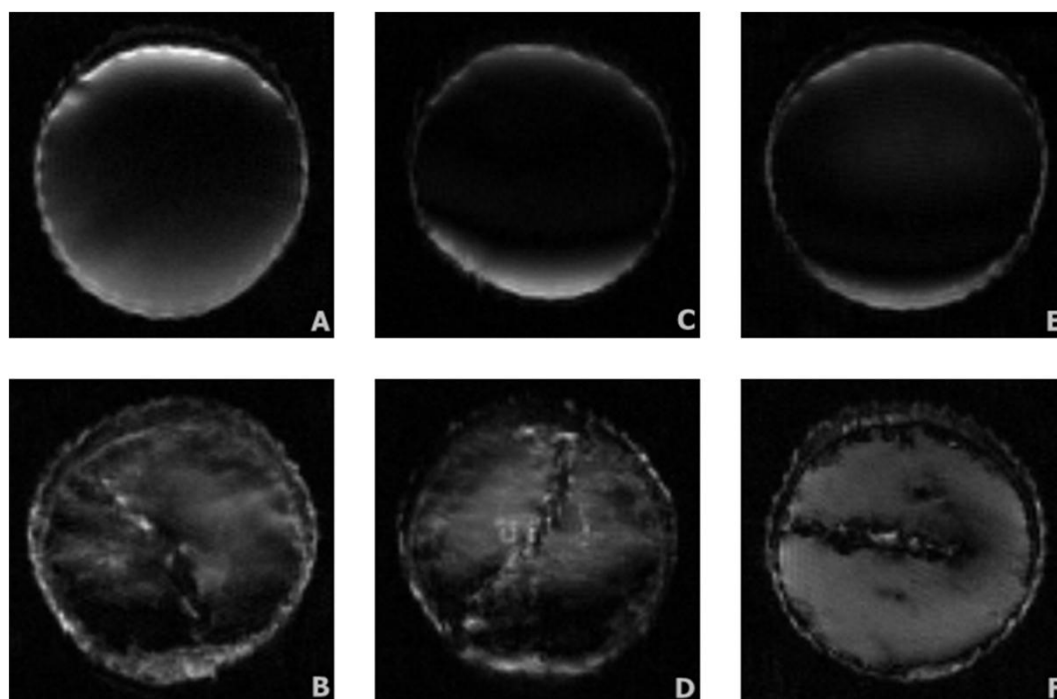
Representative water suppression coronal magnetic resonance images (MRI) of the untreated (A: 4 min, B: 16 min fried), pre-dried (C: 4 min, D: 16 min fried) and pre-coated (E: 4 min, F: 16 min fried) potatoes fried in sunflower oil at 180°C.
